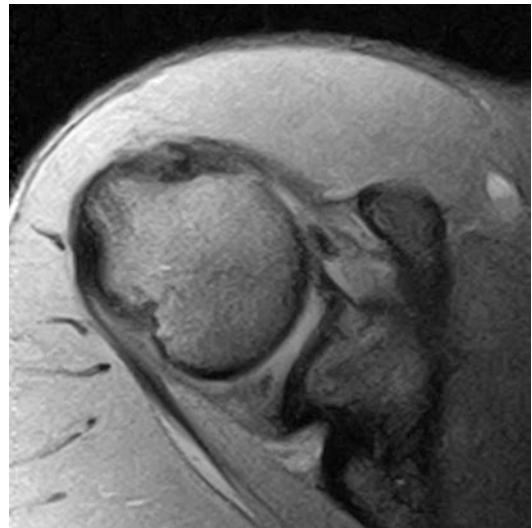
MRI axial view of a professional volleyball player showing posterior impingement signs on the humeral head and on the posterosuperior aspect of the glenoid
